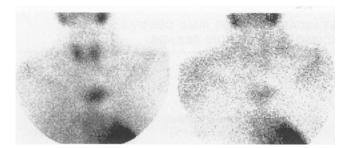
Early (*left*) and delayed (*right*) planar views of an MIBI scintigram showing a parathyroid tumor in the mediastinum. Attempted parathyroidectomy through a cervical incision was unsuccessful. Note the unusual distance of the parathyroid tumor from the thyroid gland.
